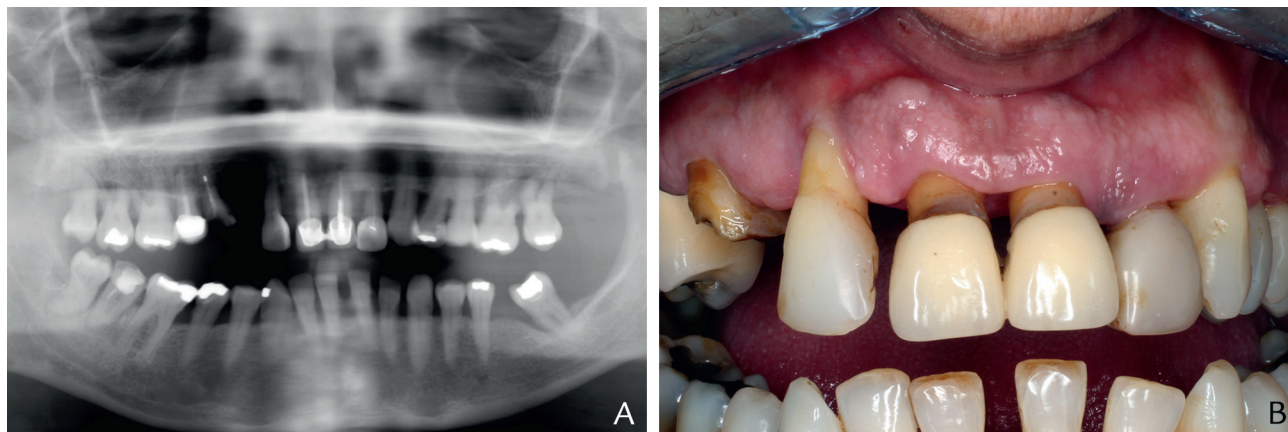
Initial patient condition. A, Panoramic radiograph. B, Intraoral view.
